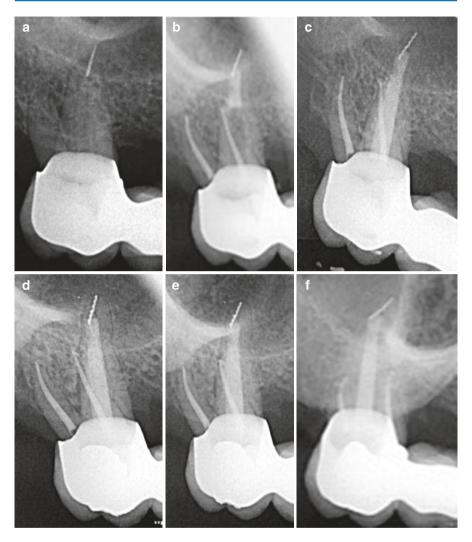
(a) A maxillary second molar with a small fragment of a #30 Hedstrom file referred for endodontic treatment. (b) Lateral perforation was created at the apical third of the palatal root during efforts to remove the fragment, and thus 4 mm of the apical third including the perforation site were sealed with MTA. (c) The remaining palatal canal was obturated with injection of thermoplasticized gutta-percha and the buccal root canal with lateral compaction of gutta-percha and epoxy-resin sealer. (d–f) The scheduled clinical and radiographic recall examinations at 6 months, a year, and 2 years, respectively, revealed uneventful healing (Courtesy Dr. K. Kodonas)
